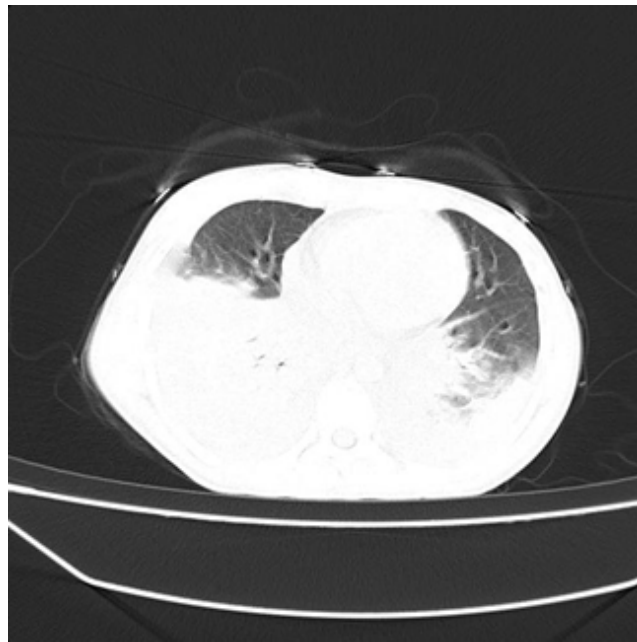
Chest CT Scan Revealed Massive Bilateral Pleural Effusion.
